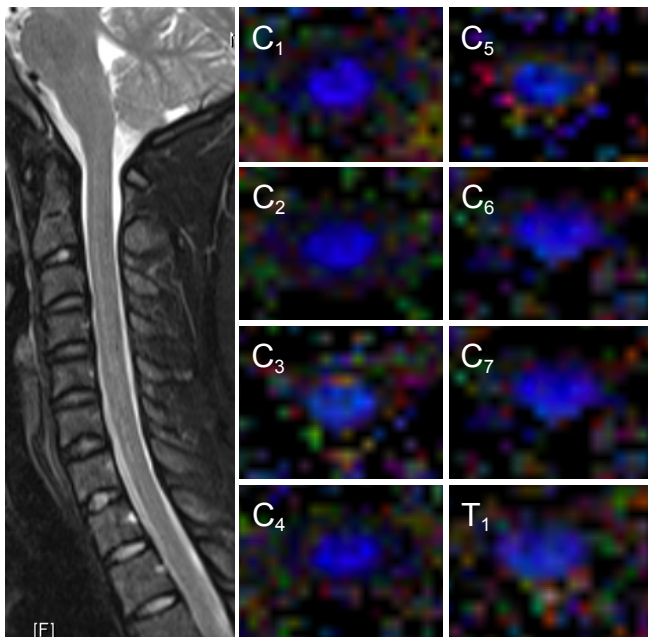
Axial fractional anisotropy maps and T2-weighted images at individual levels of the cervical spinal cord of a 28-year-old man. Images were obtained with a Siemens SKYRA 3.0T clinical magnetic resonance scanner. CoFA maps show higher anisotropy in the white matter funiculi than in the central gray matter. C₁₋₇: Cervical vertebrae 1–7; T₁: thoracic vertebra 1. FA: Fractional anisotropy.
